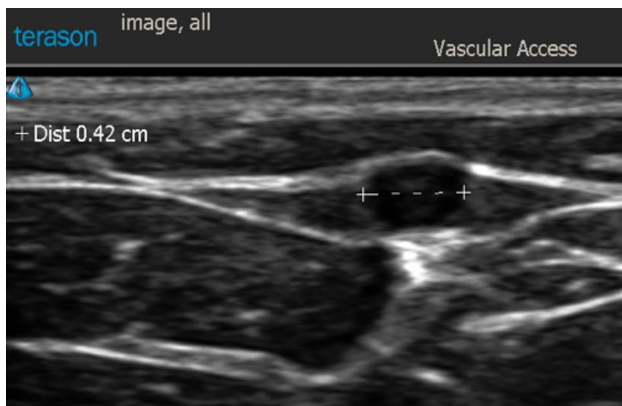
Ultrasound measurement (with calipers) of target vessel
